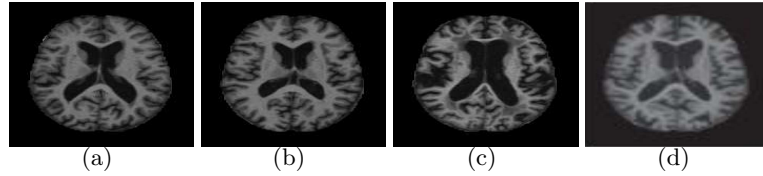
Example of different brain MRI images presenting different AD stage. (a) Non-demented; (b) very mild dementia ; (c) mild dementia; (d) moderate dementia.
